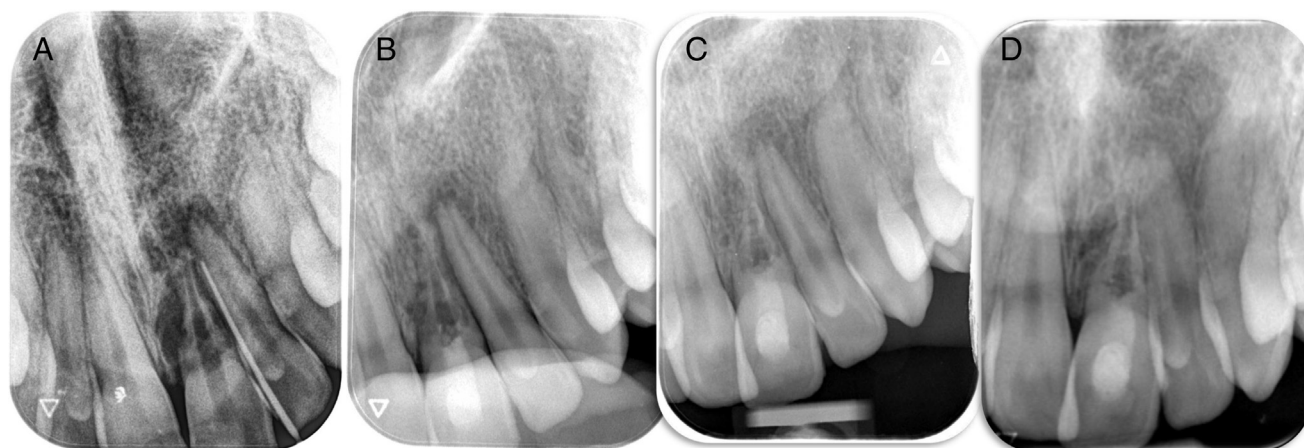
Case 3: endodontic regenerative treatment of tooth #9 after avulsion and reimplantation. (A) The preoperative periapical radiograph of tooth #9. (B) The periapical radiograph taken upon finishing the regenerative treatment. (C) The 3-month follow-up periapical radiograph. (D) The 24-month follow-up periapical radiograph.
